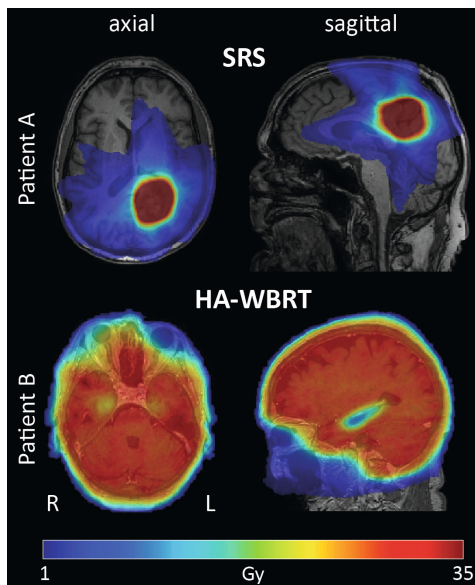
Biological dose (EQD2) distribution in stereotactic radiosurgery (SRS) and hippocampal avoidance whole-brain radiotherapy (HA-WBRT) shown on a T1-weighted MRI in axial and sagittal view (radiological orientation). Patient A was treated with 1 fraction of 15 Gy and had a single BMS in the left parietal lobe. Patient B was treated with 5 fractions of 4 Gy and had multiple BMS throughout the brain.
